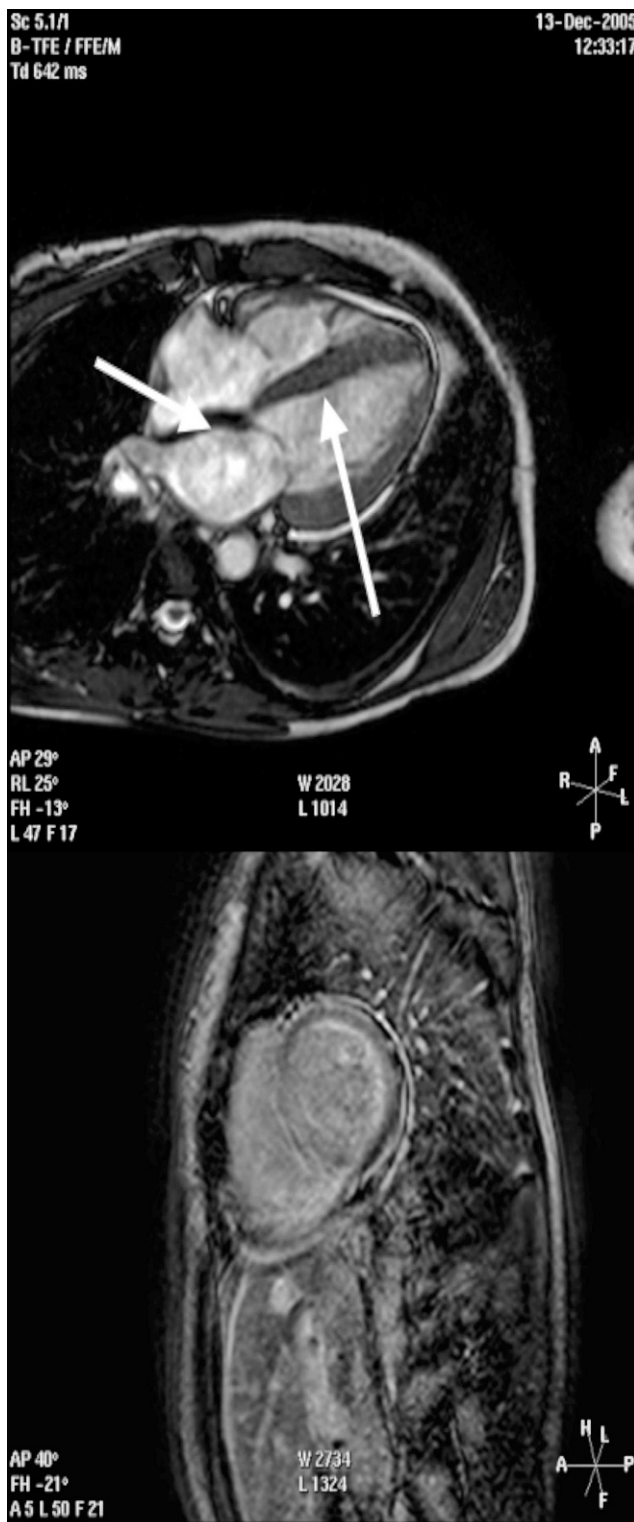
Case: 45-year-old female with rapidly progressing heart failure. Cardiac magnetic resonance imaging: Cine images, steady state free precession (top) and delayed hyperenhancement (bottom). Diagnosis: Amyloidosis—ventricular hypertrophy (top image, right arrow), thickened intra-atrial septum (top image, left arrow), and diffuse delayed hyperenhancement (bottom image).
